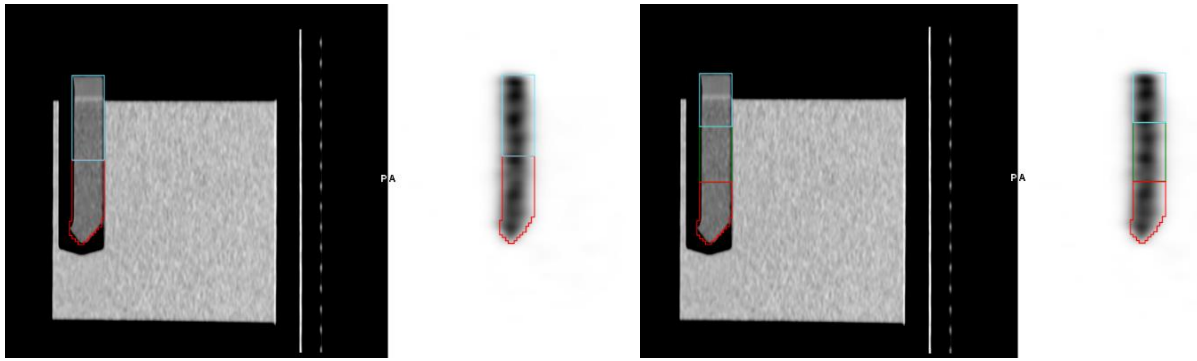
Examples of manual delineation of VOIs on the SPECT/CT in calculating the calibration factor. Left: The VOI delineation of the upper half (VOI4) and lower half (VOI5) of the source. Right: The VOI delineation of the upper third (VOI1), middle third (VOI2), and lower third (VOI3) of the source.
